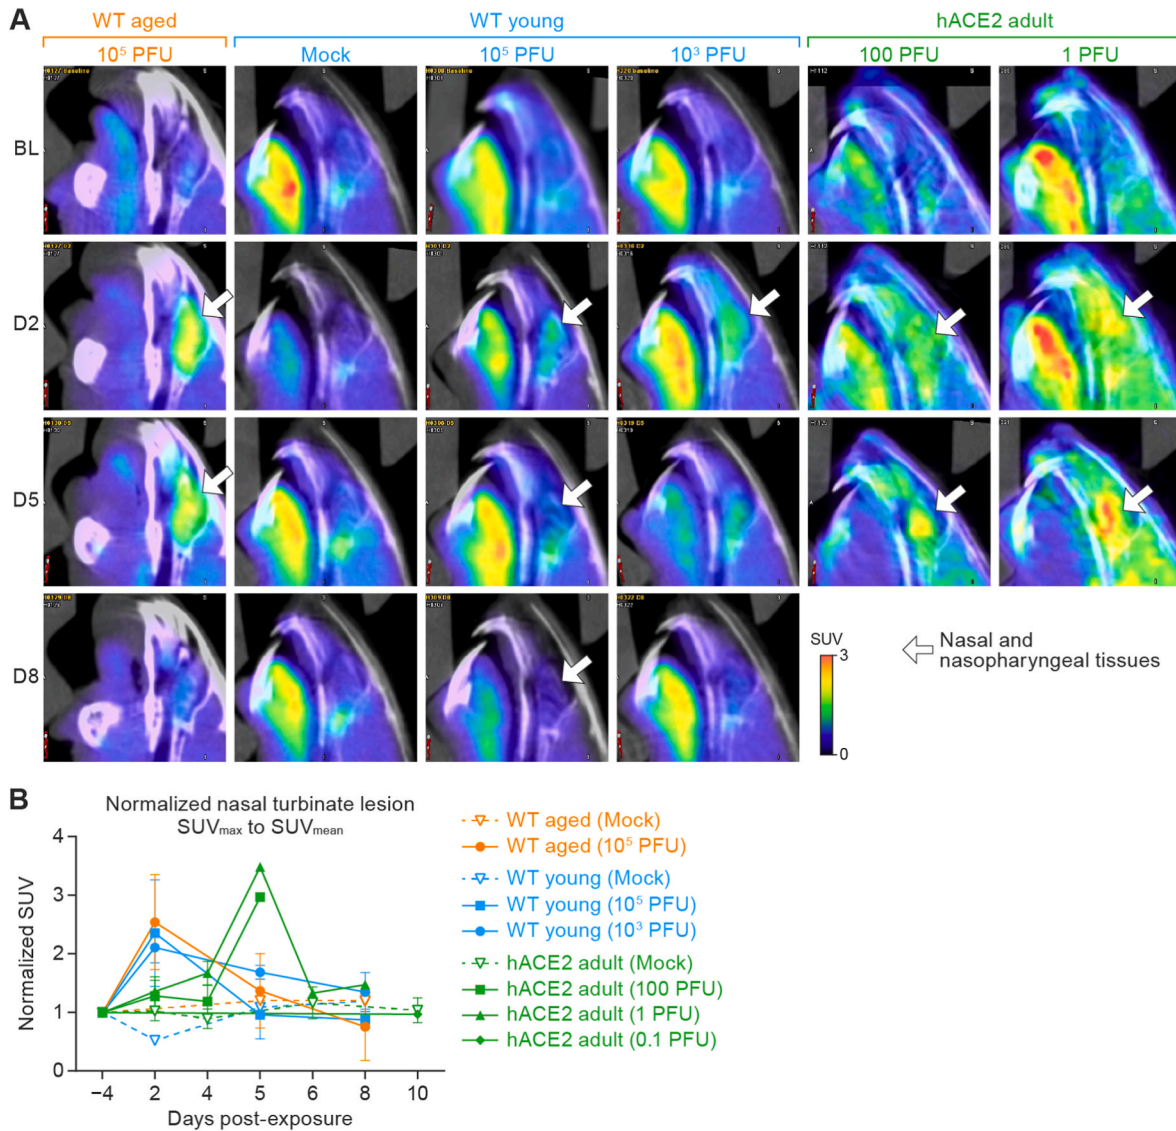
^{18}F -FDG uptake determined by tracking of the posterior nasal soft tissues using micro-PET/CT images.
